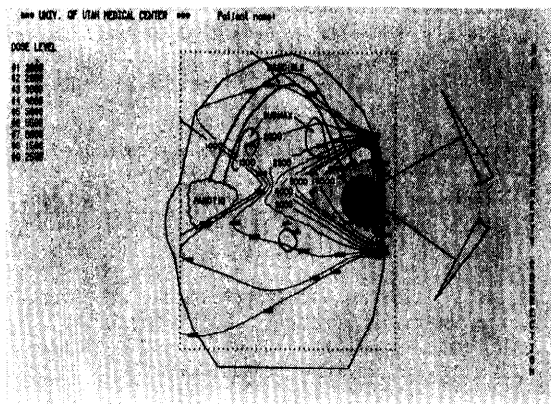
Treatment plans for parotid tumor produced by a therapy-dedicated microcomputer. A. (Left panel) Isocentric treatment plan for oblique fields of 4 MeV x-rays with 60° wedges. Note good coverage of tumor and adjacent parotid gland. B. (Right panel) Same setup but with 40% of the dose given by direct lateral field with 15 MeV electrons. The dose distribution is improved by decreasing the dose to the contralateral mouth and submaxillary gland and to the spinal cord.
